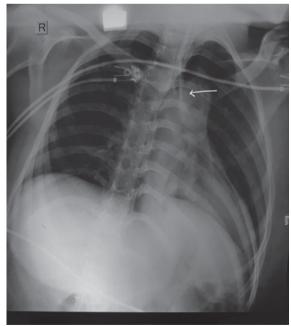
Chest X-Ray showing foreign body protruding out of distal end of endotracheal tube (Day 1 of admission)
